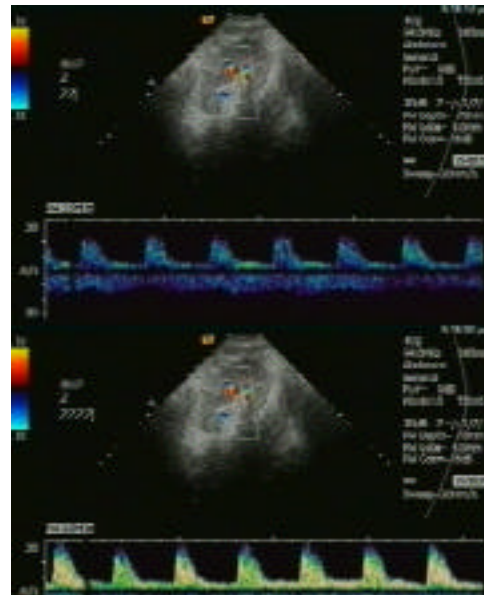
Example of in vivo spectral Doppler enhancement in the renal pedicle of a patient after Kidnet transplant
